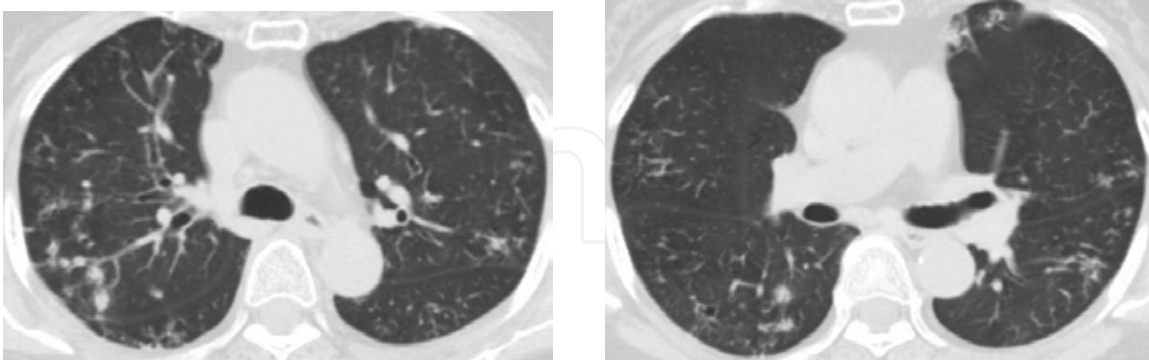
HRCT images of the lungs of a 69-year-old woman with MAC-PD. Multiple diffuse, small, centrinodular nodules and tree-in bud opacities were seen in the all lobes.
